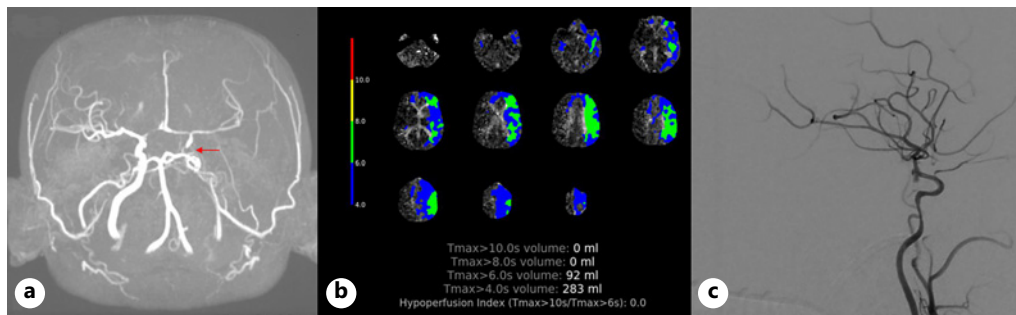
a MR angiography: occlusion of the left intracranial tract of the internal carotid artery and multiple severe intracranial stenosis. b CT perfusion: large area of ischemic penumbra in the territory of the left MCA. c Angiography: complete recanalization after intracranial stenting in distal carotid siphon-left MCA.
